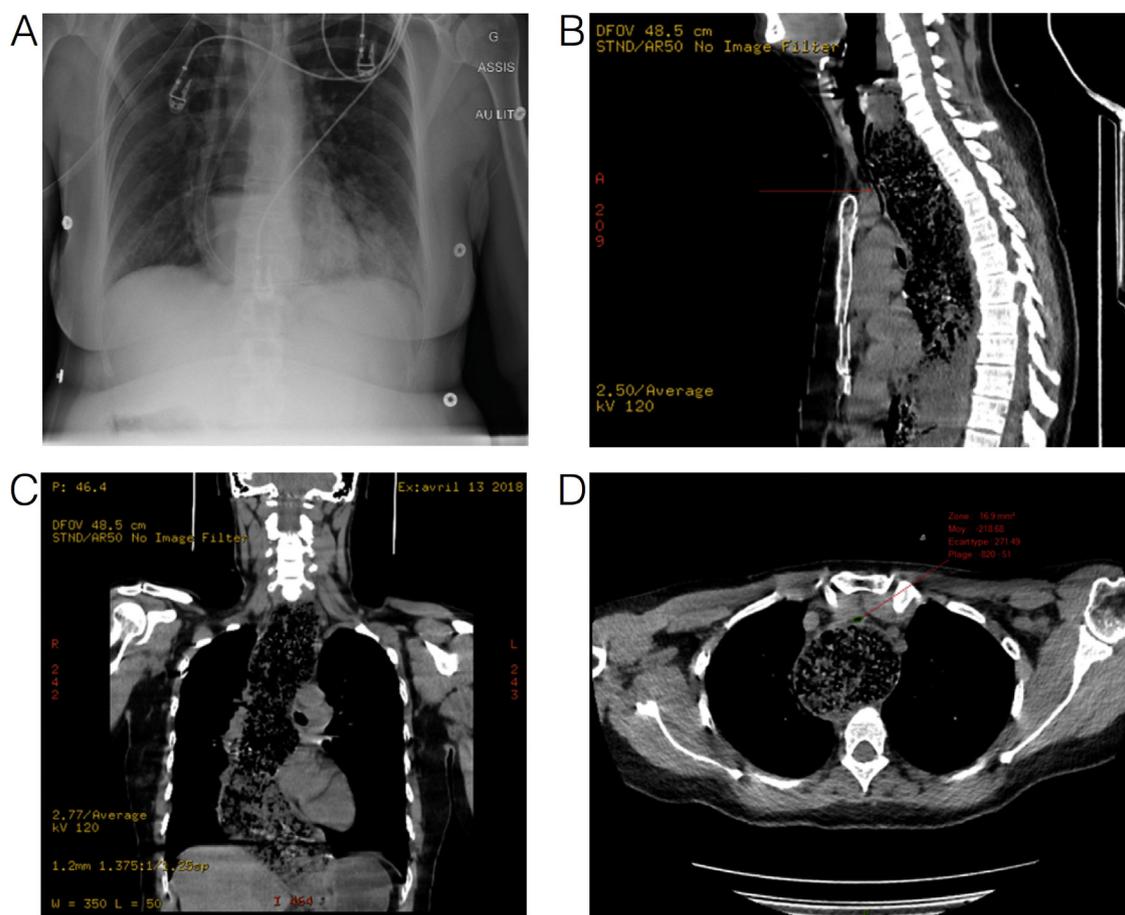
Anteroposterior supine chest X-ray (A) and sagittal (B), coronal (C) and axial (D) CT scan showing a massive enlargement of the esophagus extended to the lower esophageal sphincter with tracheal compression (red arrow) at the level of manubrium sterni. At this level, trachea cross sectional area was measured at 16.4 mm² (green; normal value of 250 mm²).
